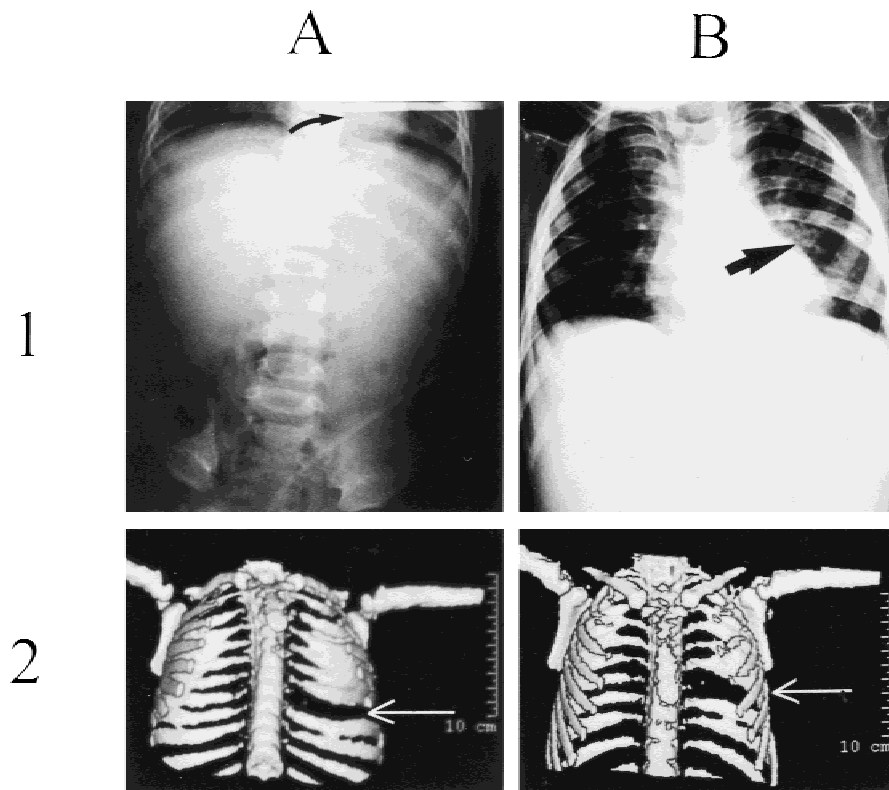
Osteolytic lesion of the left eighth rib. (Row 1, A) The left eighth rib (arrow) was intact when the boy was 5 month-old. (Row 1, B) Complete destruction of the left eighth rib (arrow) was shown when the boy was 30 month-old. (Row 2, A) A three dimension CT image showed the absence of left eighth rib. (Row 2, B) Ten degree sagittal tilt of a three dimension CT image as shown in Row 2, A.
